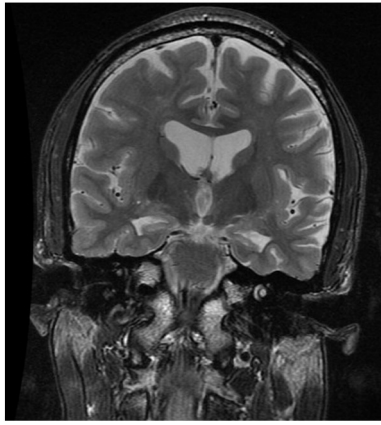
Coronal T2 MRI showing bilateral left > right hippocampal atrophy.
